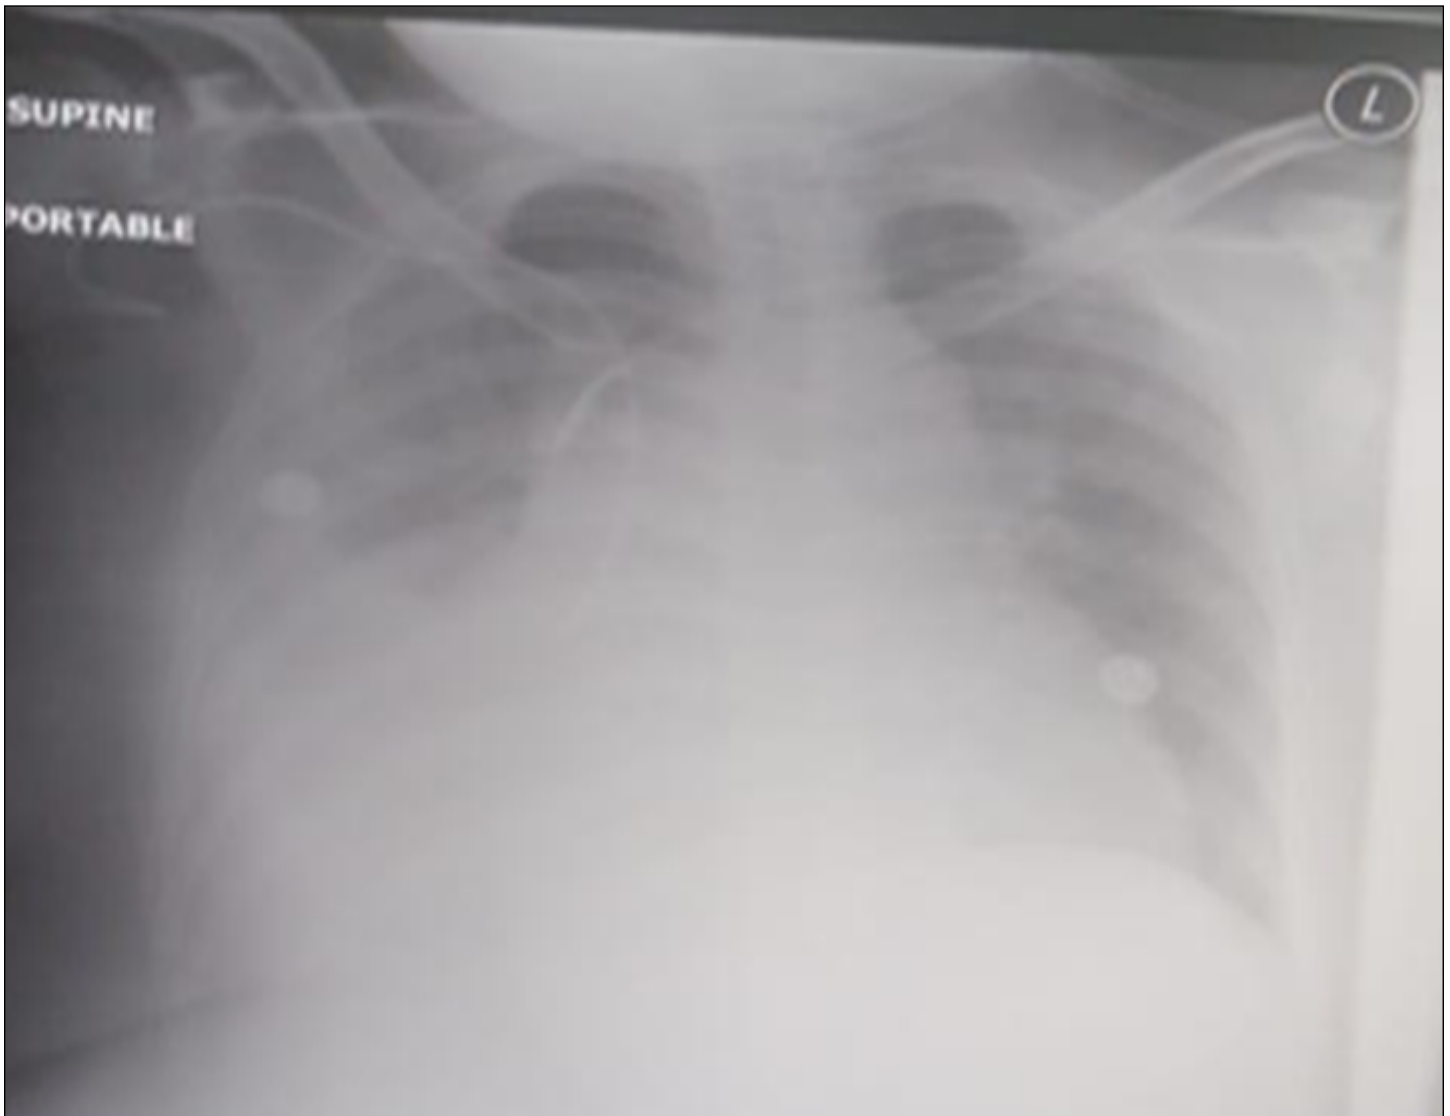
Chest x-ray showed bilateral pleural effusion with pulmonary congestion.
